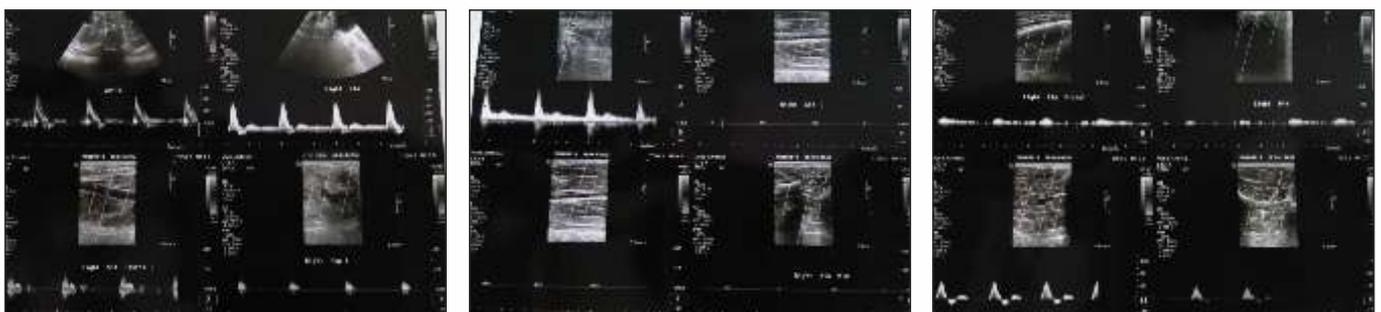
Pre-operative arterial doppler
